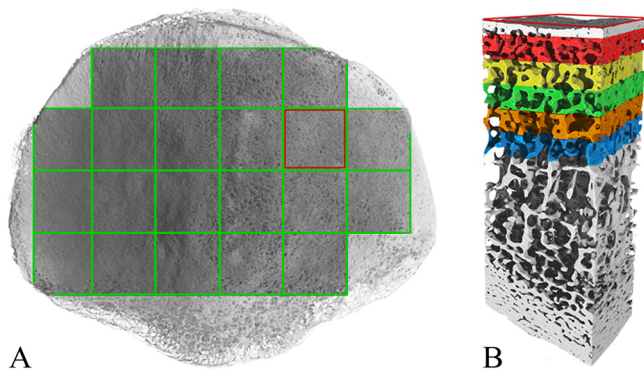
Method of μ -CT; definition of measurement cube and regions of interest. (A) 3D reconstruction, left patella in dorsal view, 21 areas for extraction of measurement cubes marked. (B) Measurement cube with 5 highlighted regions of interest (1st ROI: red; 2nd ROI: yellow; 3rd ROI: green; 4th ROI: orange; 5th ROI: blue) just below the subchondral bone plate. (For interpretation of the references to color in this figure legend, the reader is referred to the web version of this article.)
